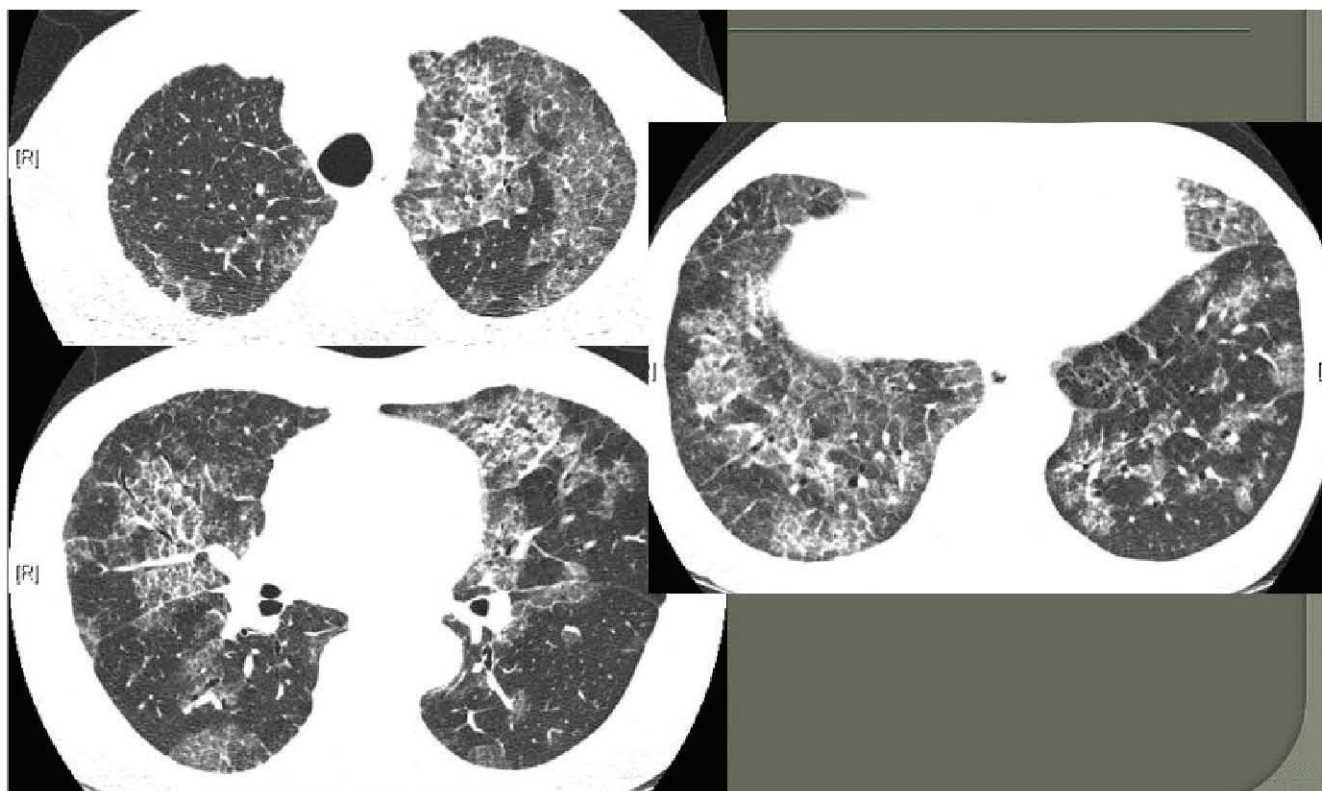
HRCT at presentation
